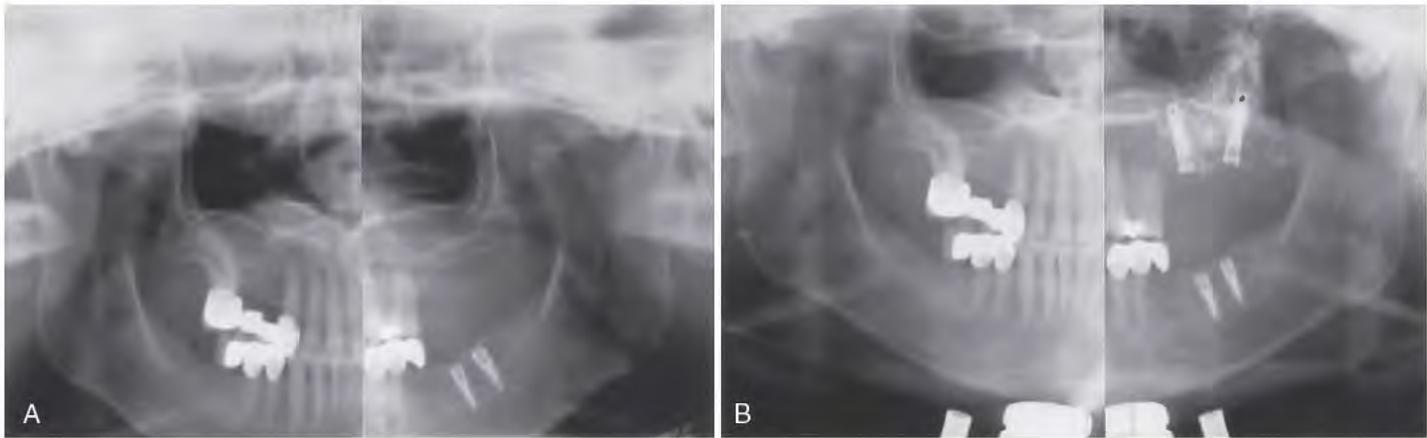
A, A radiograph shows a sufficient amount of bone to allow placement of endosteal implants at the time of grafting. B, A postoperative Panorex film shows the acceptance of a combination of autogenous and synthetic graft materials, which have embodied two 15-mm long Steri-Oss implants.
